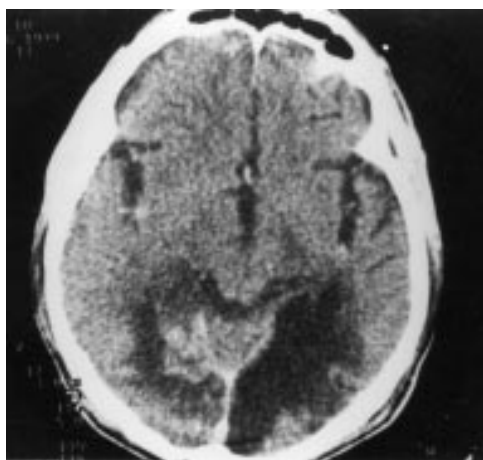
Cranial computed tomography (CT) showing bilateral infarction of occipital lobes. CT picture consistent with "top of basilar syndrome." In contrast to posterior leukoencephalopathy, there is marked involvement of the paramedian visual cortex.
